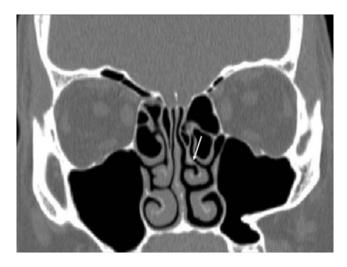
Coronal CT showing left sided paradoxical middle turbinate (arrow)
